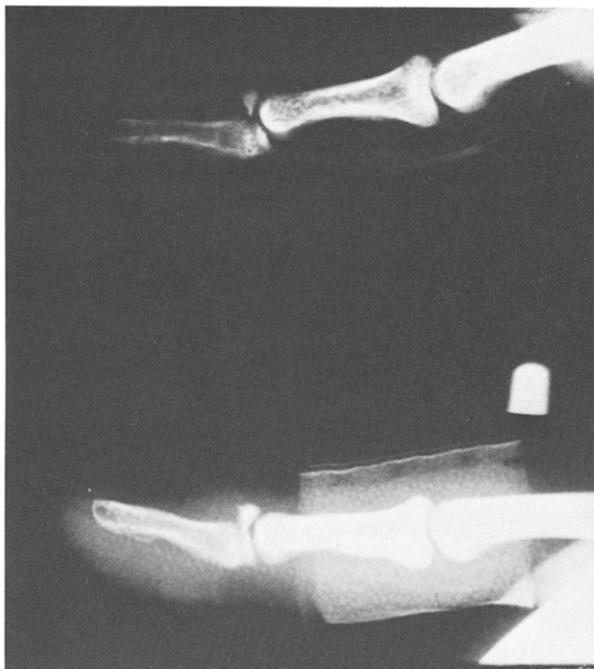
Top radiograph* shows the palmar subluxation of the shaft of the distal phalanx. *Lower radiograph* shows successful reduction of this subluxation after splint application with tape layering of the proximal palmar margin of the splint.
